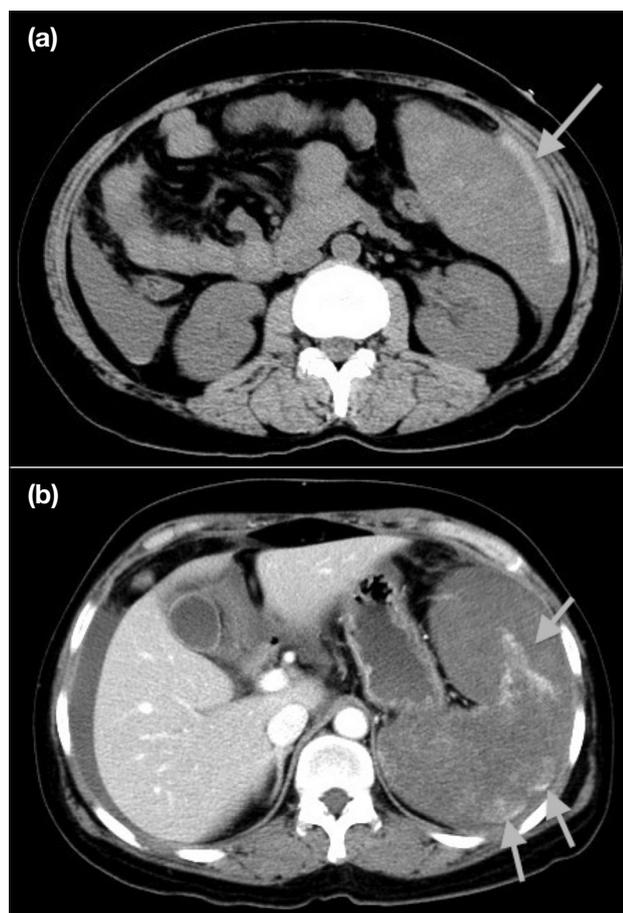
Computed tomography scans of the abdomen and pelvis showing (a) high attenuation fluid at the prehepatic space suggestive of haemoperitoneum with a sentinel clot at the perisplenic region (arrow); and (b) gross haemoperitoneum and contrast extravasation at the dependent region of the spleen (arrows).
